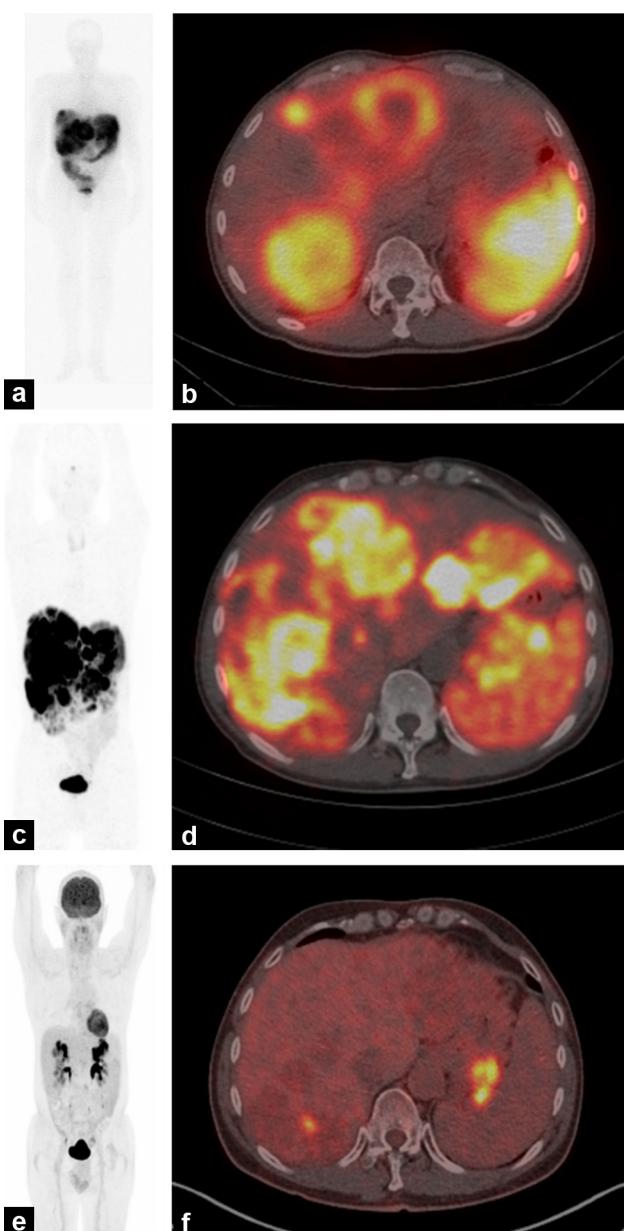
Patient with liver metastases from well differentiated pancreas neuroendocrine tumor. ^{111}In -pentetetotide single photon emission tomography (Octreoscan) (a and b) shows high uptake of somatostatin analogue in liver lesions. ^{68}Ga DOTATOC PET/CT (c and d) shows more liver lesions compared to Octreoscan in the same patient. FDG PET/CT (e and f) was negative according to the well differentiated tumor feature.
